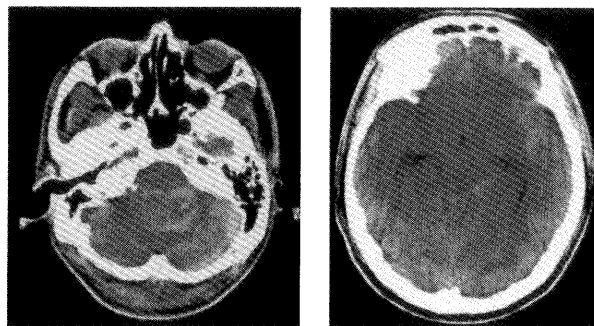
CT on admission showed SAH and left cerebellar hemorrhage. Acute hydrocephalus was also recognized.
